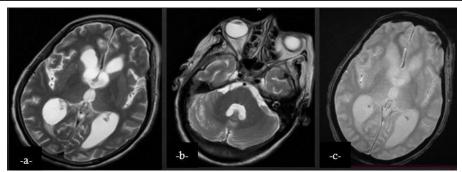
Cerebral MRI in axial sections showing quadriventricular dilation without visible obstacle with slight widening of the lateral fissures on T2-weighted sequences (a, b). Absence of anomaly on SWI sequence (c). Findings compatible with normal-pressure hydrocephalus
